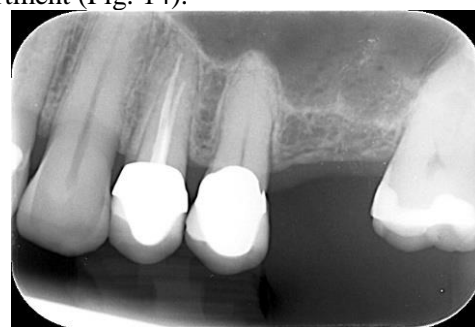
Pre-operative periapical radiograph of #2.6 area showing crestal height <5 mm.
